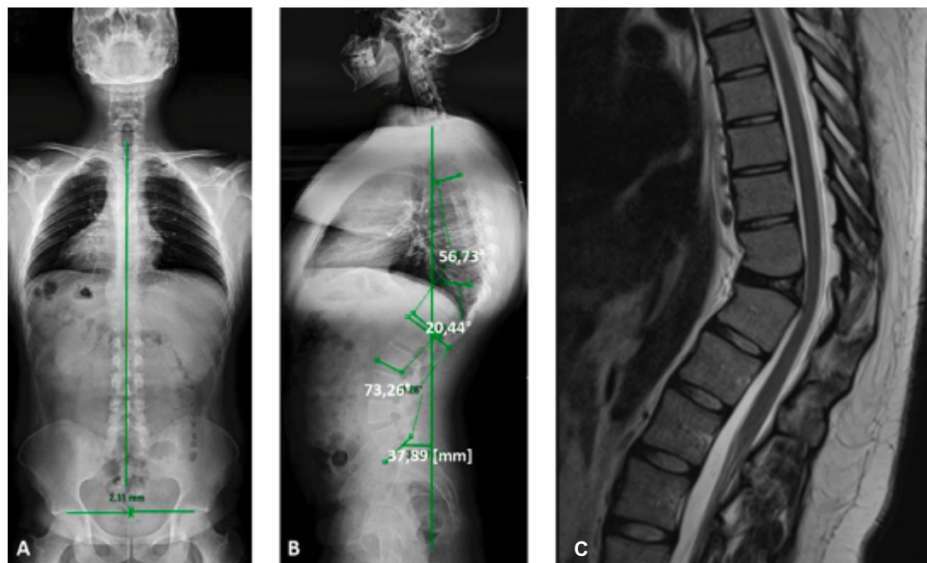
Anterior-posterior X-ray shows an aligned spine (A). Lateral X-ray shows T10 butterfly vertebra with abnormal T9-T11 thoracic kyphosis. It also observed 37 mm negative sagittal balance, 73° of lumbar lordosis, 56° of thoracic kyphosis (B). Sagittal magnetic resonance imaging shows the T10 butterfly vertebra characteristics (C).
